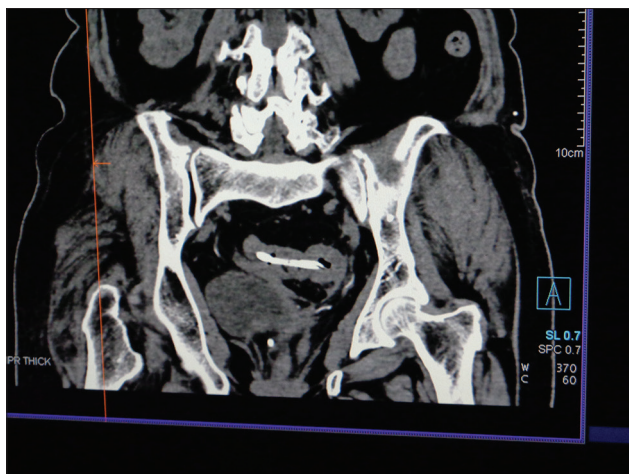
Computed tomography scan showing stent in sigmoid colon
